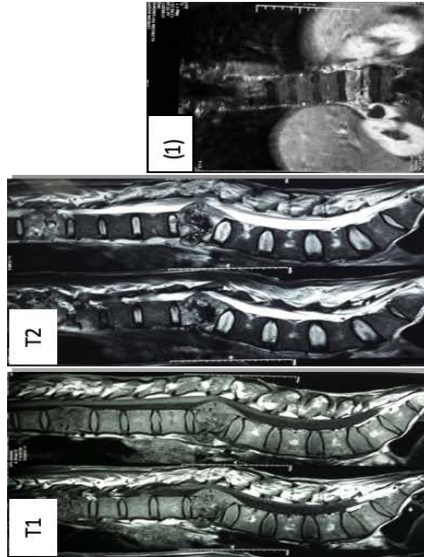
MRI (T1 & T2) showing paraspinous abscess and psoas abscess (1).
